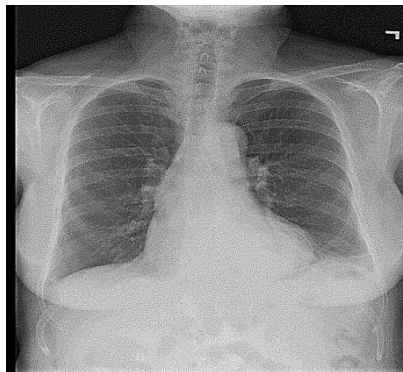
Cardiomegaly Chest X-ray
